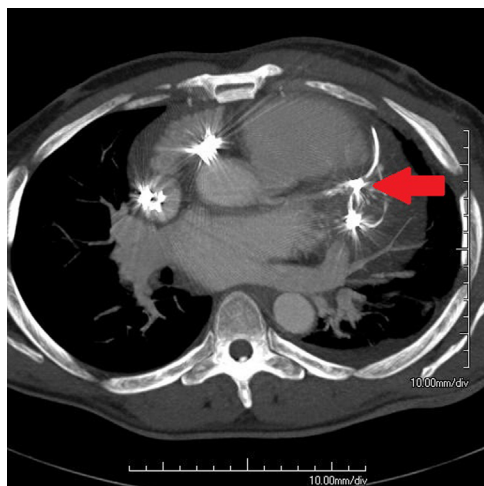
Nongated chest computed tomography scan completed 2 months prior to admission indicating an epicardial pacing lead in close proximity to the left anterior descending artery (arrow).
